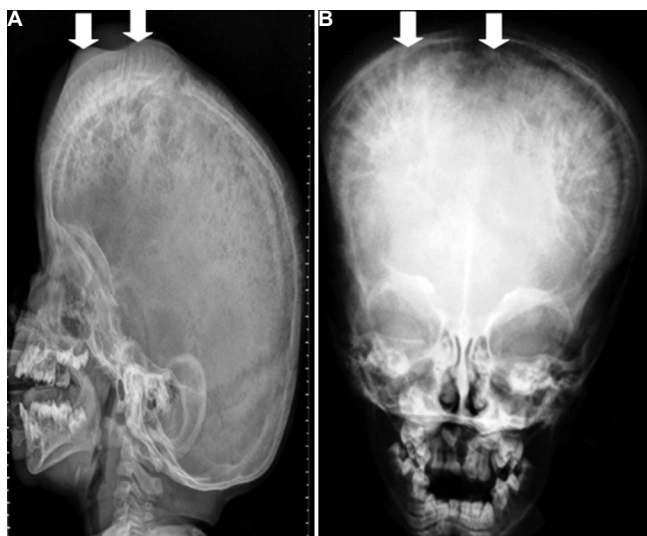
X-ray of the skull (A) lateral and (B) anteroposterior view - multiple lytic-sclerotic lesions (arrows) involving skull vault with a large soft tissue component.
